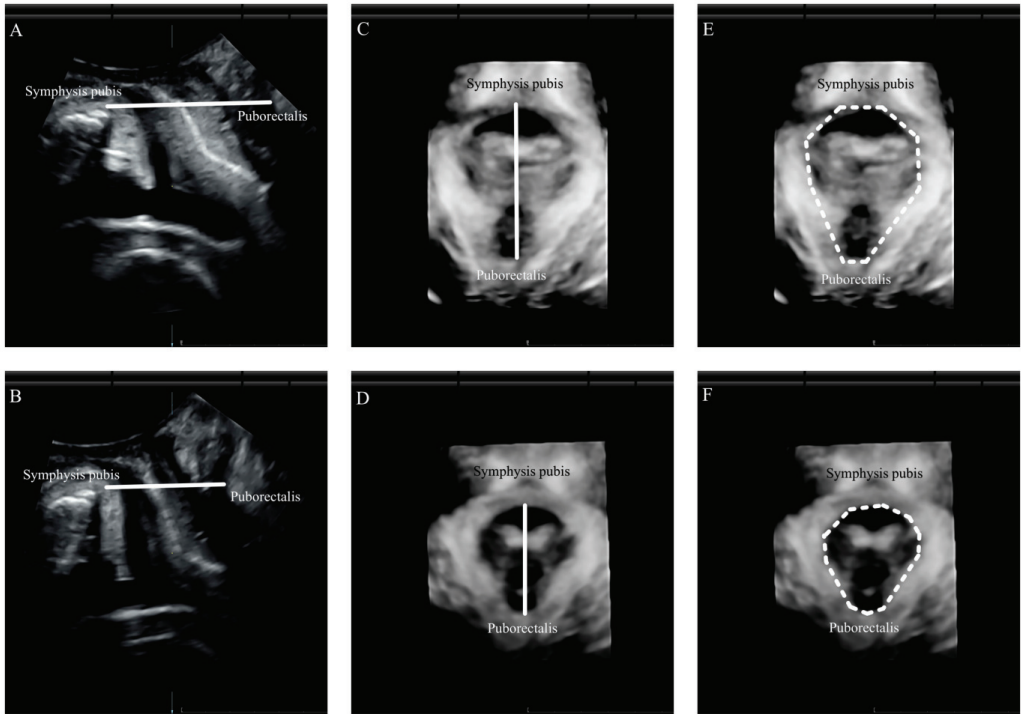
Quantification of pelvic floor contraction using transperineal ultrasound. Measurements of the levator hiatus anteroposterior diameter from the inferior margin of the symphysis pubis to the medial margin of the musculus puborectalis in 2D at rest (A), at contraction (B) and in 3D at rest (C) and contraction (D). Hiatal area at rest (E) and contraction (F). With permission from Wiley.
